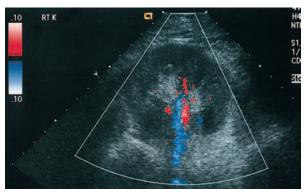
Ultrasound evaluation of kidney. Transverse color Doppler image shows the artery as *red* and the vein as *blue*.
